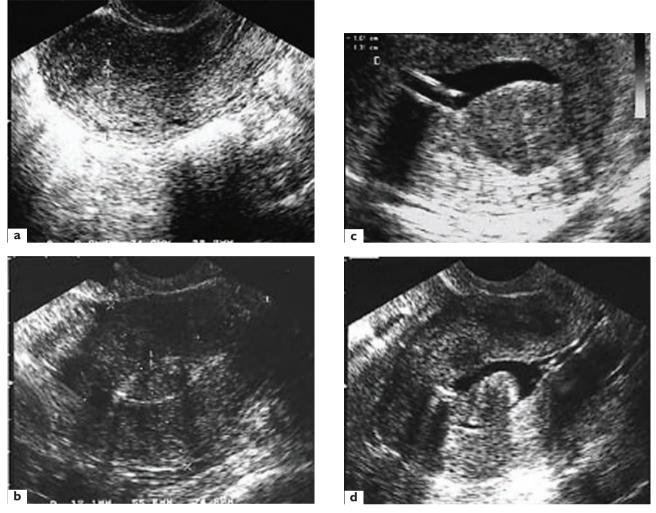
A 40-year-old patient with menorrhagia. Transvaginal sonography shows (a) a sagittal view of the endometrium of 6-mm thickness; and (b) endometrial thickness with a small focus at 12 mm; (c) and (d) saline infusion sonohysterography gives visualization of a polyp
